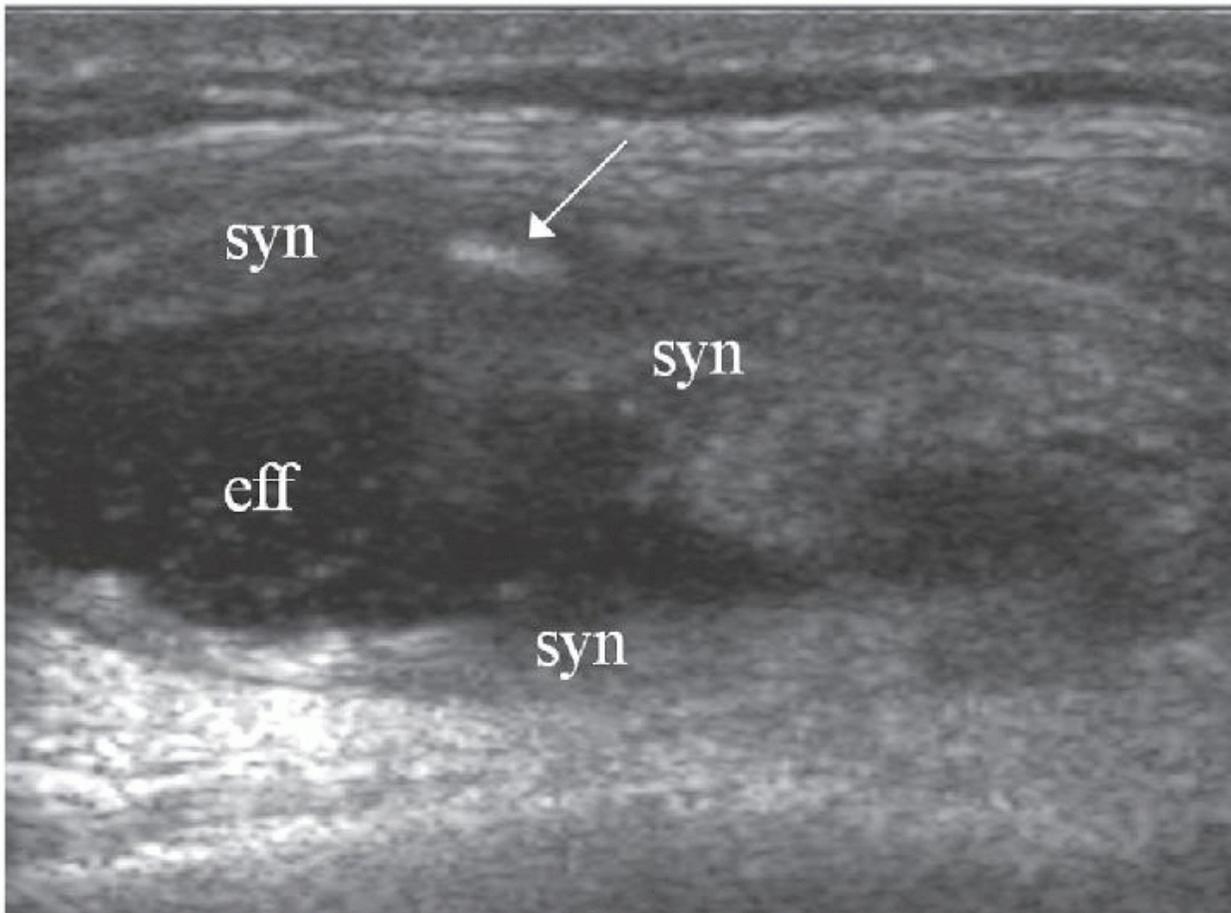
Osteochondromatosis of the knee. Ultrasound shows effusion (eff) and synovial hypertrophy (syn) in the knee recess. Calcification in the thickened synovial wall is seen (arrow).
